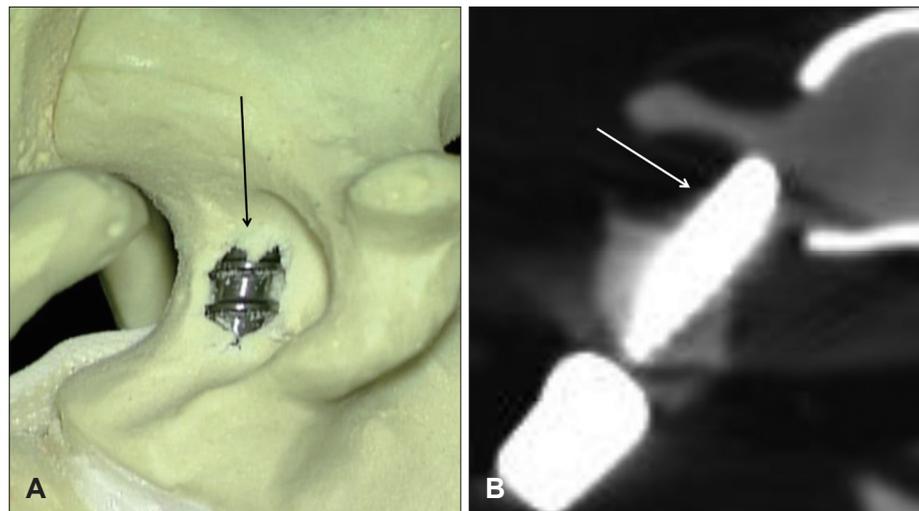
During the procedure, pedicle perforation (arrow) is directly visualized on sawbone model (A), and post-procedural CT of sa bone model shows grade 1 perforation (B).
